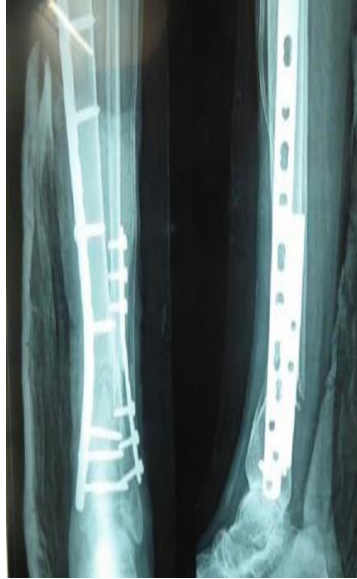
Sutured wound and immediate post-operative X-ray
